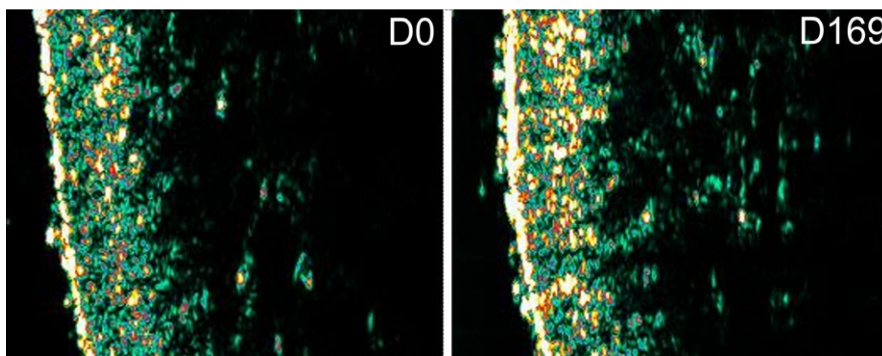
Ultrasonography images assessing the subepidermal low echogenic band of the malar area of subject number 6
